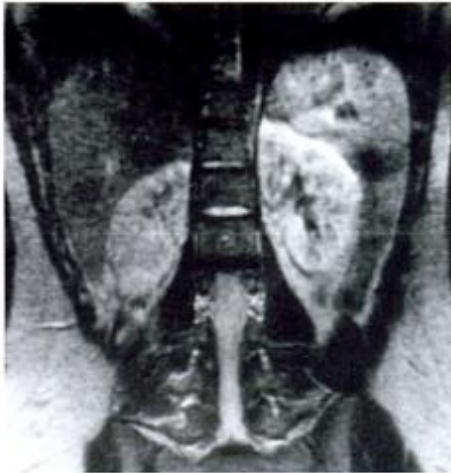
Magnetic resonance image of stone patient treated with extracorporeal shock wave lithotripsy demonstrating loss of corticomedullary junction demarcation in right kidney.
